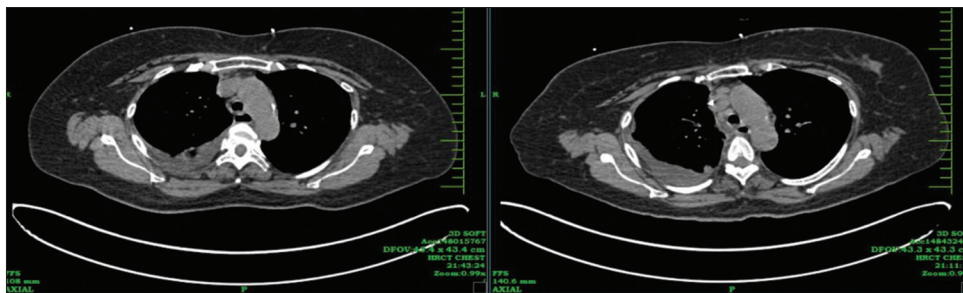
Repeat high-resolution computed tomography CHEST performed after 5 days demonstrating good clearance of consolidation in right lower zone following treatment
